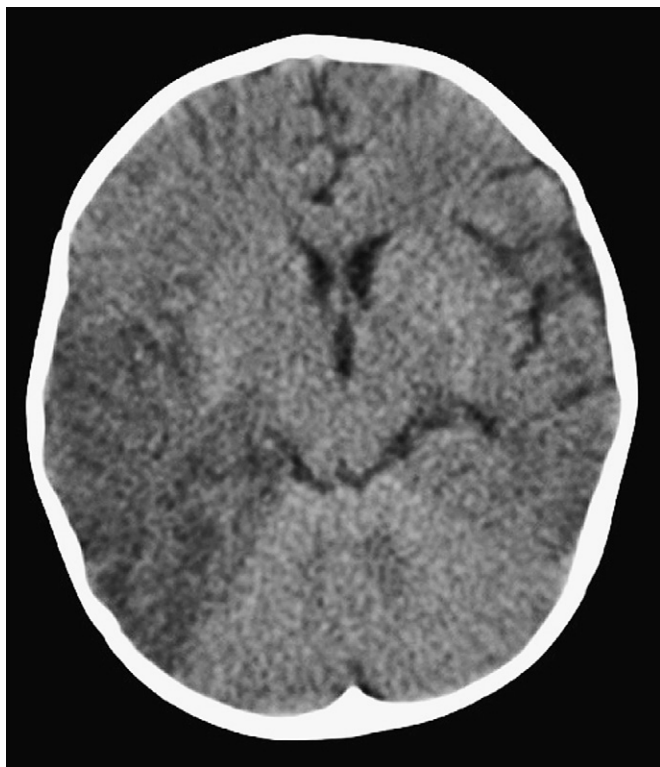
A magnetic resonance image of a pediatric patient with herpes simplex encephalitis. The image demonstrates the attenuation of the white matter of the right temporal lobe.
